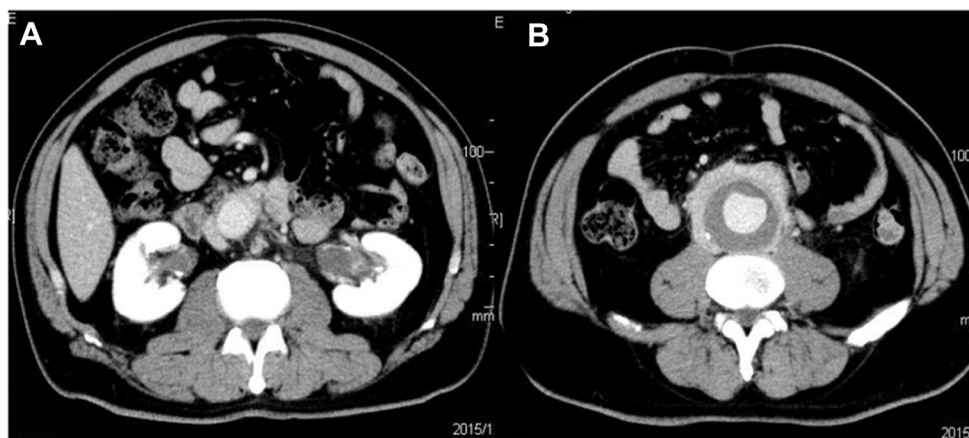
Computed tomography (CT) scan showing abdominal aortic aneurysm (AAA), bilateral hydronephrosis (A), and aortic wall thickening (B).
